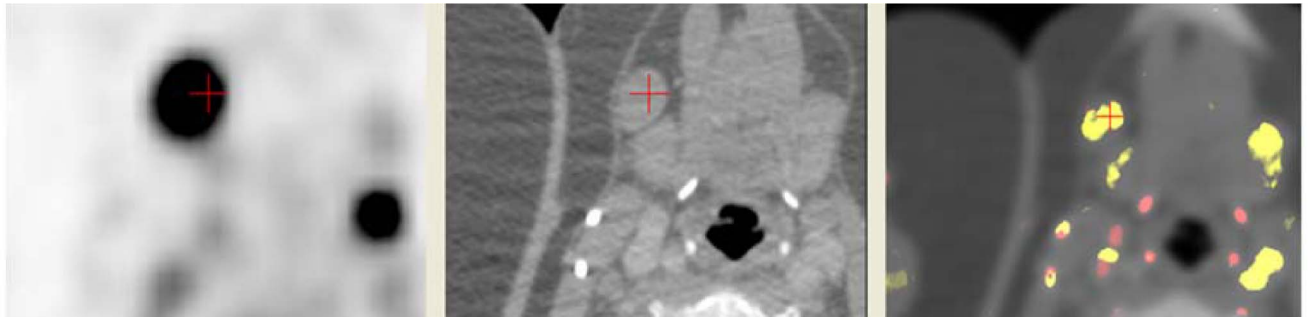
Combined PET/CT scan after FDG injection, left: PET, middle: CT slice, right: slab-MIP with shape-encoding rendering, all coregistered. A lymphoma lesion close to the maxilla manifests as a FDG-hot spot (cross-hair) in the PET image (left), and is also color coded in the shape-encoding rendering (right, RST approach). The shape-encoding rendering can help to easier distinguish between hot spot stemming from spherical lymph nodes versus others stemming from brown fat.
